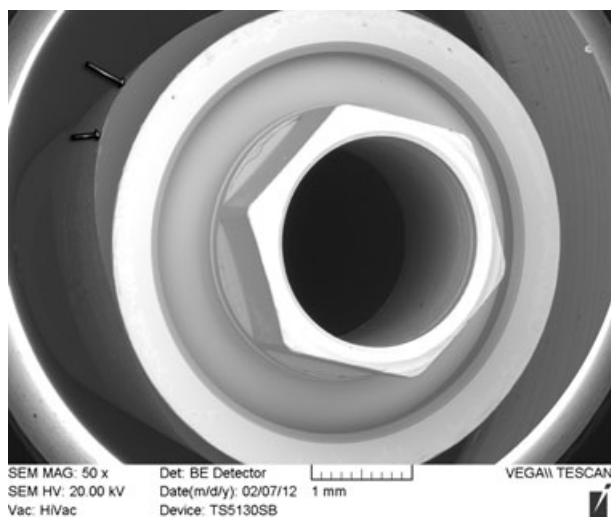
Test group 1 connection (ultrasonic cleaning): no pollution is revealed ($\times 50$). Arrows highlight finishing line.
